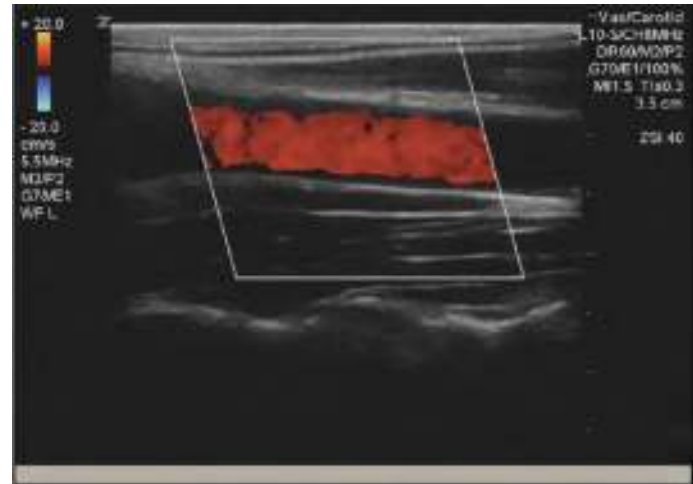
The color Doppler box, or region of interest (ROI), placed over the carotid artery reveals flow in the direction of the transducer (red).
